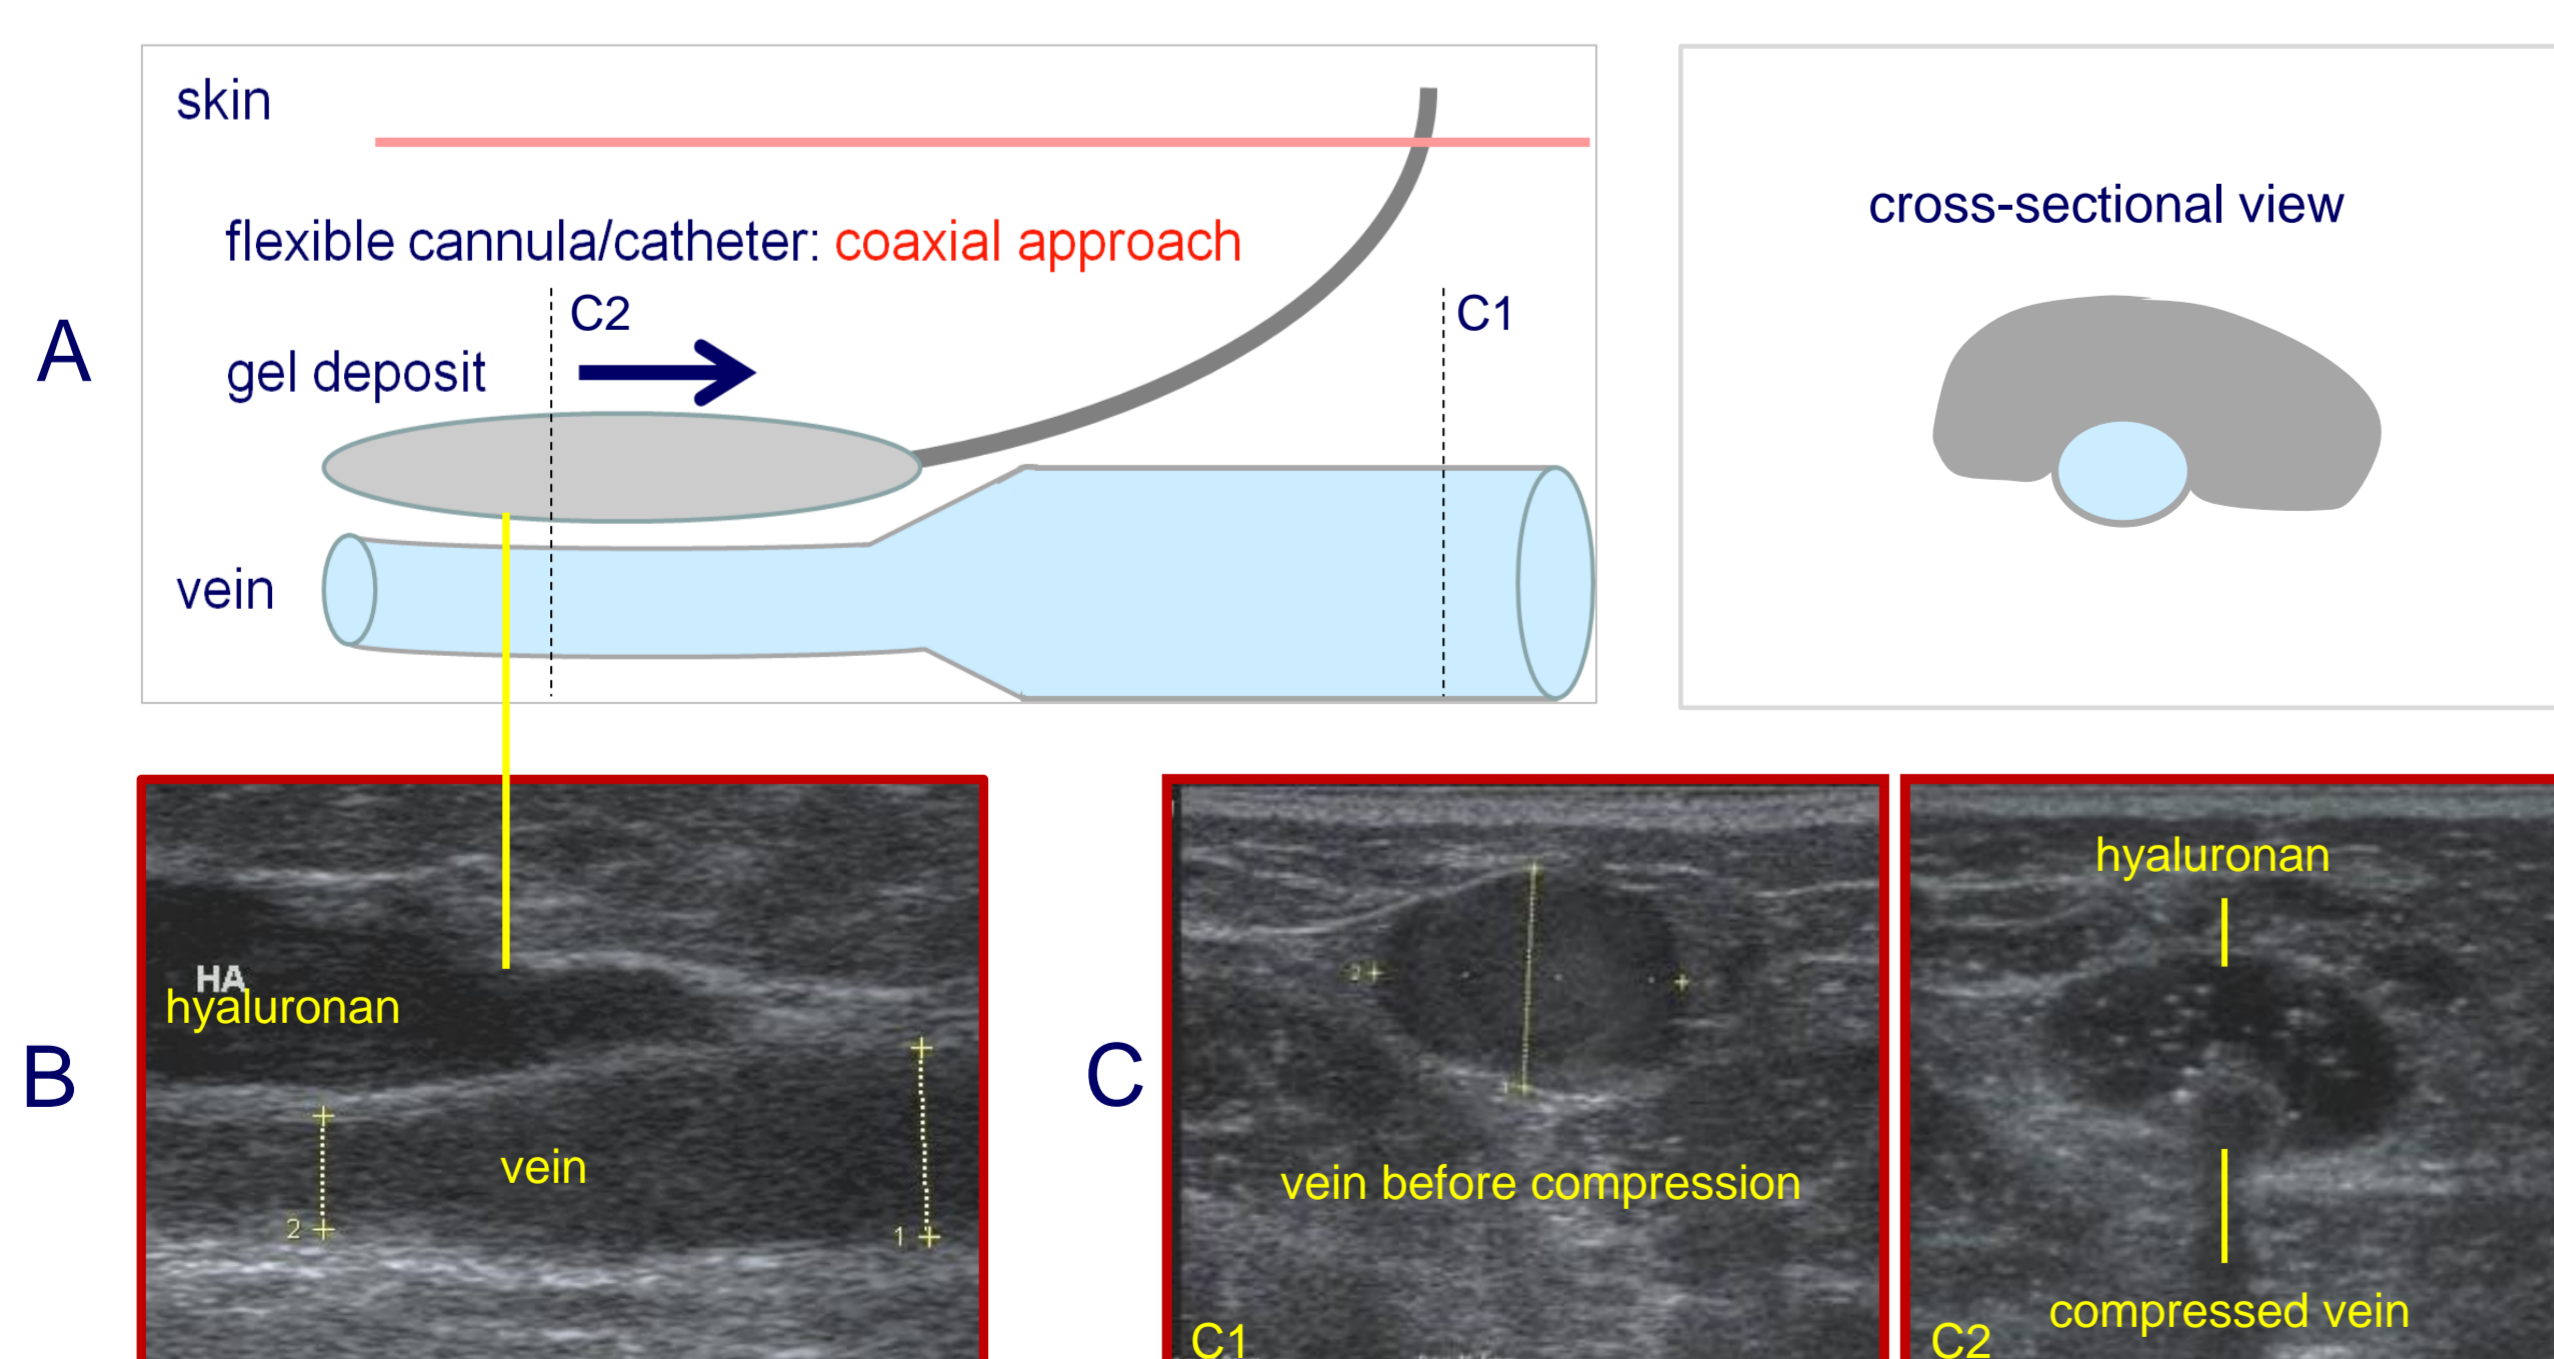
Hyaluronan injection accompanying foam sclerotherapy, A) scheme, B) ultrasound longitudinal view; C) vein before and after hyaluronan injection, cross sectional view
